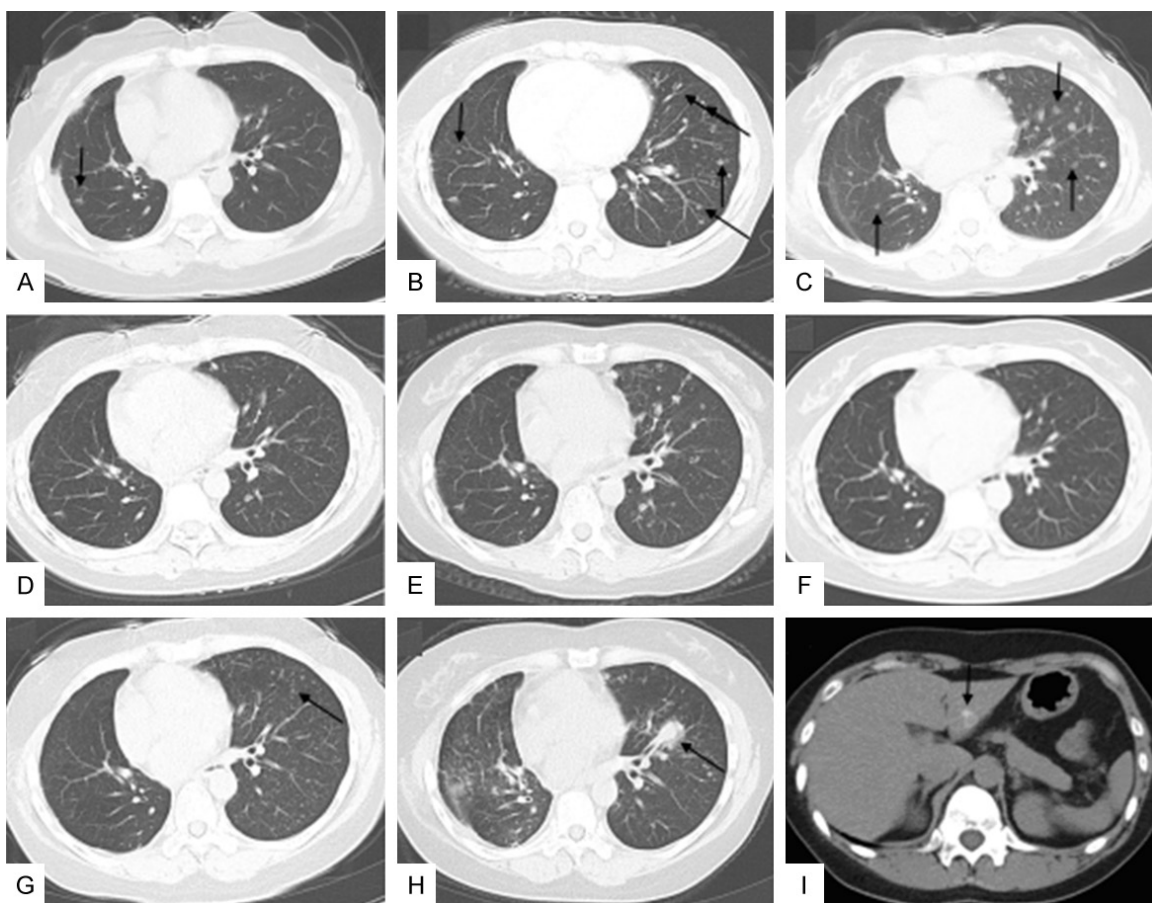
Computed tomography (CT) of the chest and abdomen after different therapies. A. A new nodule in the right lower lobe and right pleural effusion after postoperative radiotherapy and chemotherapy (August 2011). B. Multiple metastases in the lungs (June 2012). C. Further metastatic nodules in the lungs after treatment with erlotinib for 1 month (July 2012). D. Fewer metastatic nodules in the lungs during chemotherapy administration (cisplatin and pemetrexed) [November 2012]. E. More metastases in the lungs 4 months after sequential therapy with docetaxel and afatinib (May 2013). F. No significant metastases in both lungs after crizotinib treatment for 8 months (January 2014). G, H. New metastases in the lungs after crizotinib treatment for 14 months and 20 months, respectively (July 2014, January 2015). I. A metastasis appeared in the left lobe of the liver (October 2014).
